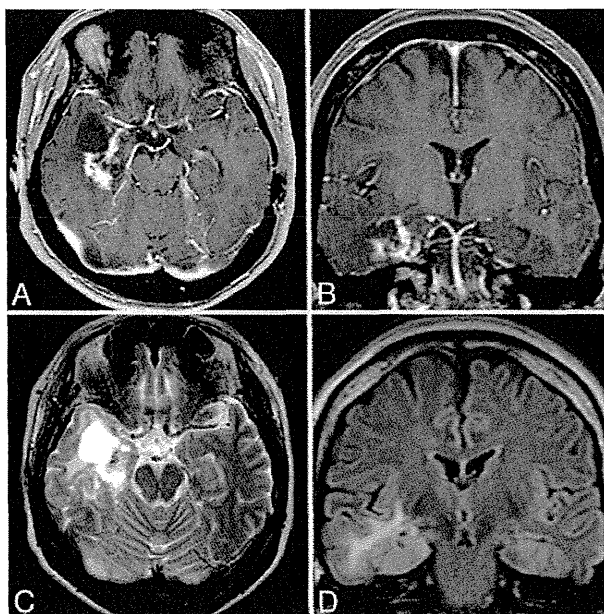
Case 5. Magnetic resonance images. Gadolinium-enhanced (A and B), T2-weighted (C), and FLAIR (D) images obtained 10 years after GKS show that a Gd-enhanced lesion and surrounding edema in the temporal lobe remain and cyst formation is observed in the temporal lobe.
